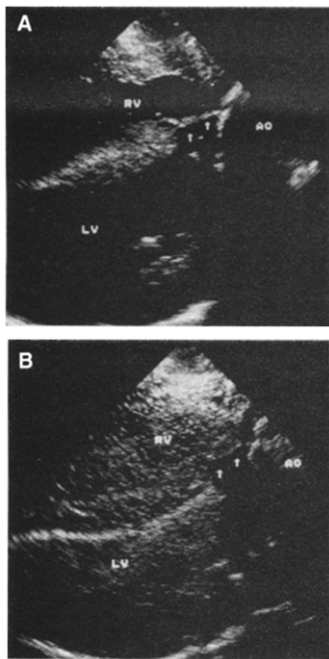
A, postbypass epicardial two-dimensional echocardiographic imaging in a long-axis view after correction of tetralogy of Fallot. The two-dimensional image clearly demonstrates the ventricular patch (arrows) to be in situ; there are no signs of patch dehiscence. B, The subsequent contrast echocardiographic study reveals a uniform and dense contrast effect in the right ventricle (RV), which exceeds 50% of the contrast effect in the left ventricle (LV), indicating grade III residual shunting. The large area of echo masking posterior to the prosthetic patch (arrows) is also well demonstrated. AO = ascending aorta.
